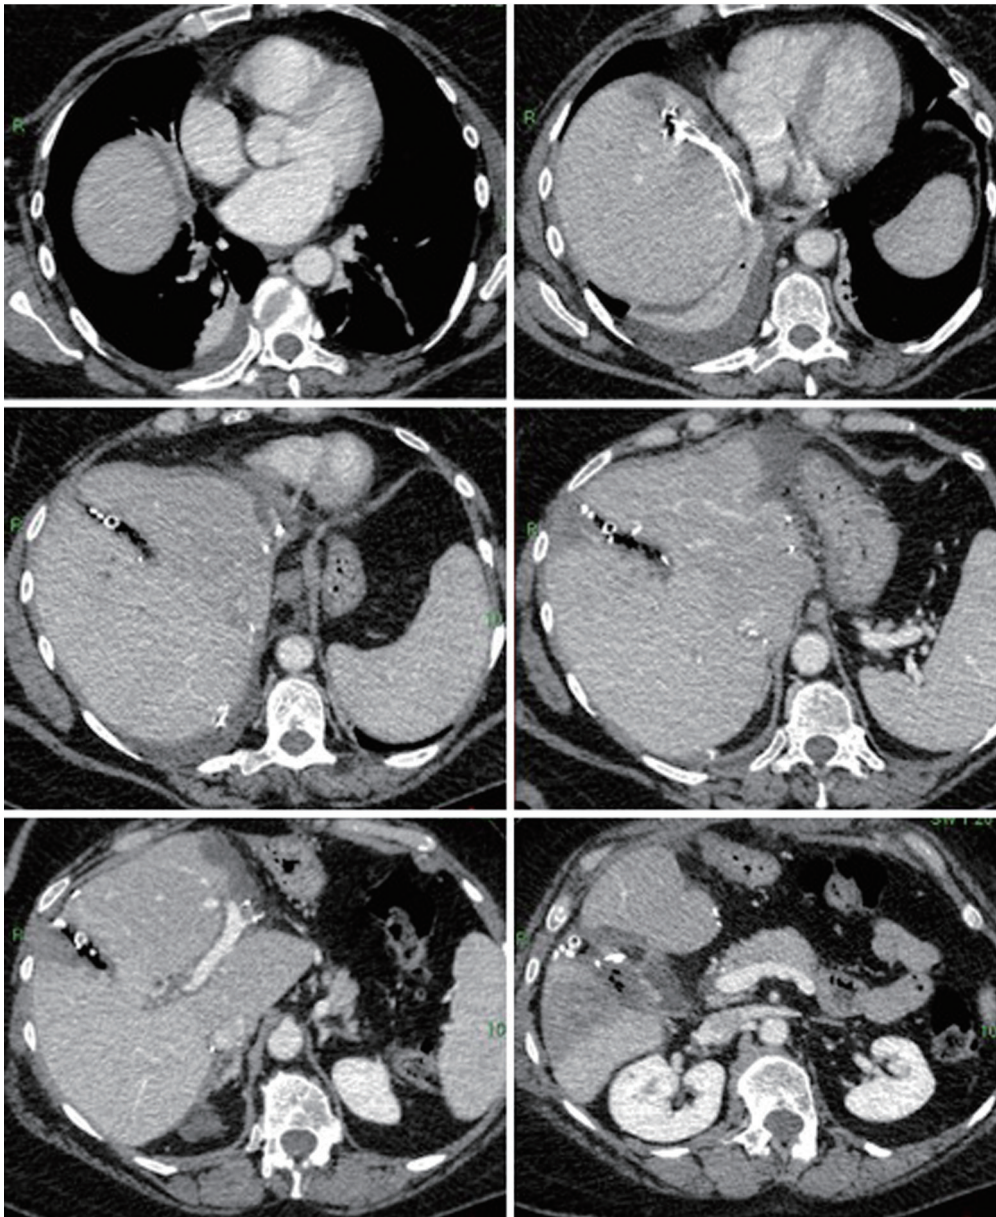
Before second stage triple phase CT liver showing increase of FLR in patient 1.
